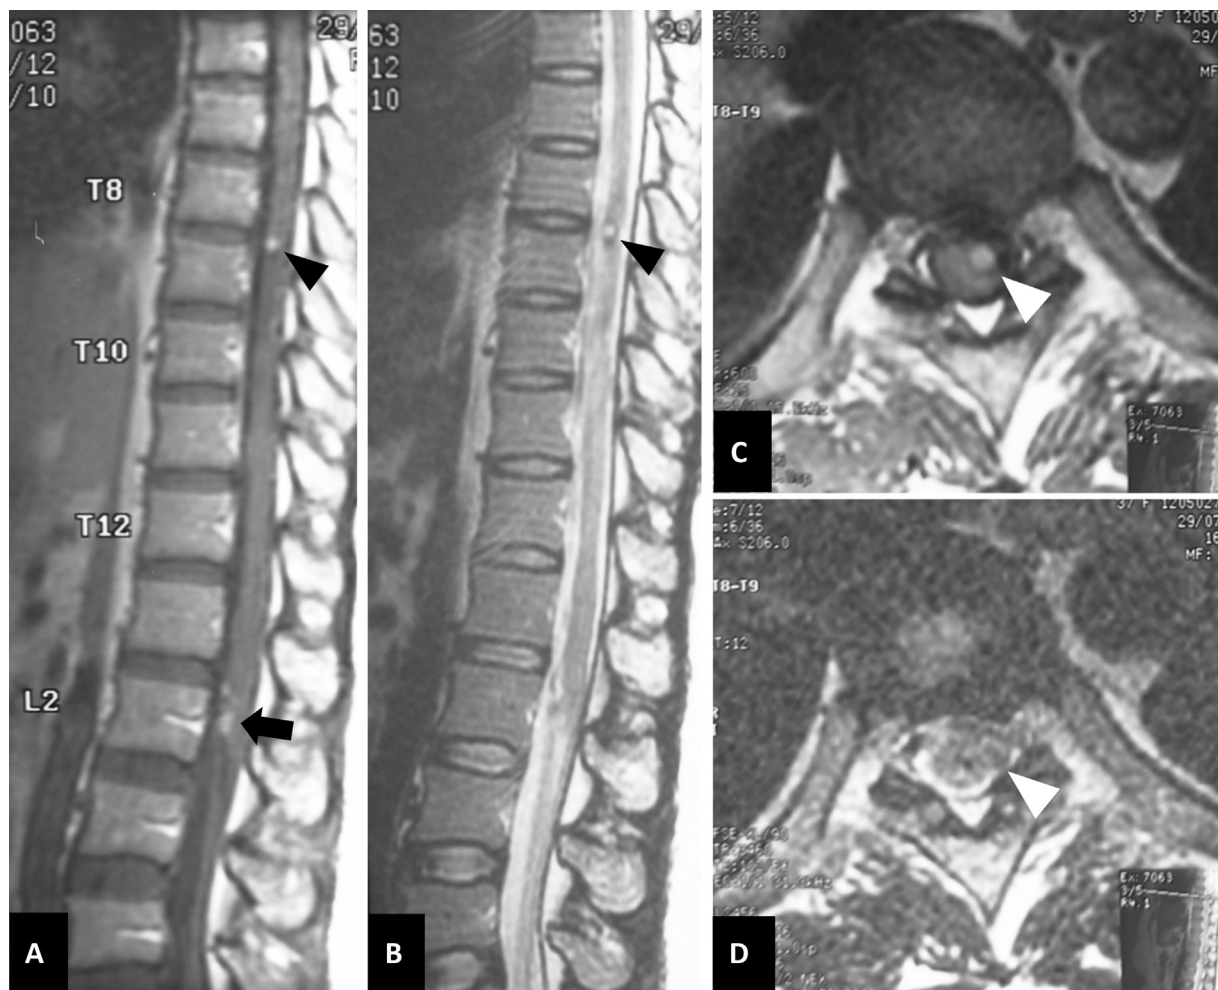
Magnetic resonance imaging of the thoracic spine obtained 2 months after endovascular treatment. At the level of T8–9 on the anterolateral cord, (A) sagittal and (C) axial T1-weighted images show hypersignal intensity, and (B) sagittal and (D) axial T2-weighted images demonstrate hypersignal intensity surrounding with hyposignal intensity (black and white arrowheads), probably indicating thrombosed venous aneurysm. There are multiple small hypersignal intensity foci (black arrow) at the level of L2 just above the distal end of the conus medullaris, probably representing thrombosed venous pouch.
